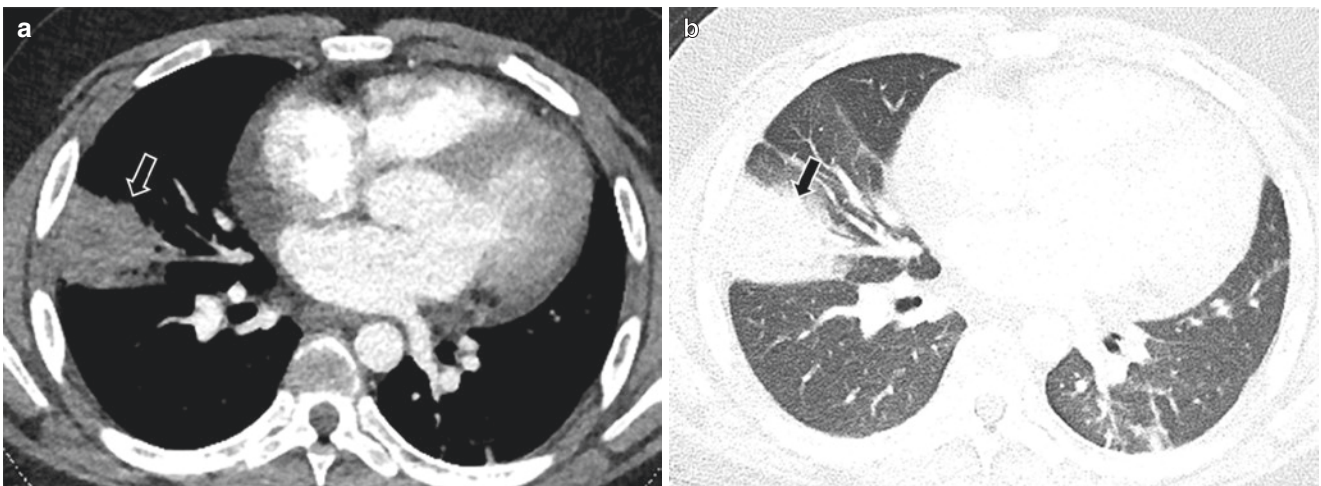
A 15-year-old boy with acute lymphocytic leukemia. Axial CT images from a CTPA study in soft tissue (a) and lung (b) windows demonstrate a peripheral wedge-shaped consolidative opacity (black arrow) in the right lower lobe, suspicious for pulmonary infarction
